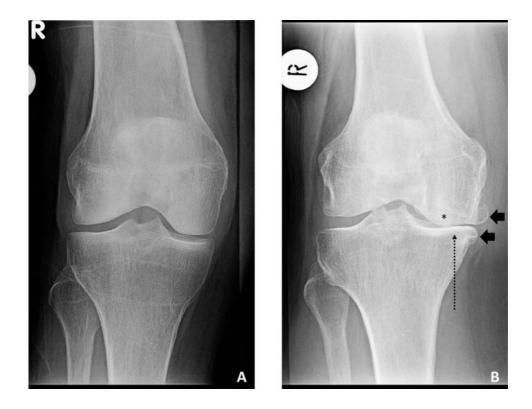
Comparison of the radiographic appearance of a normal knee (A) and an osteoarthritic knee (B) $(^{125})$
